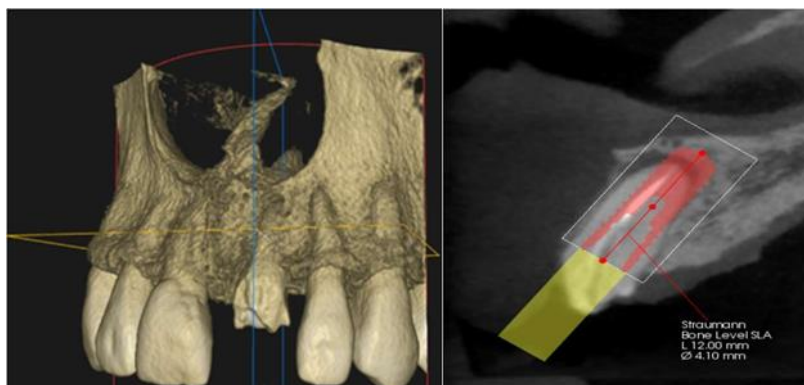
Pre-operative CBCT examination
